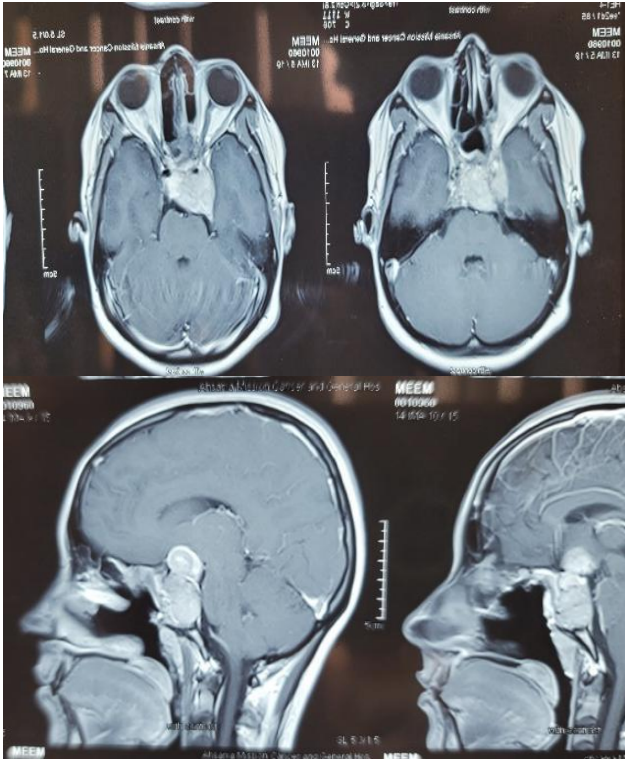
MRI of brain at 20th POD showing residual lesion measuring 2.4×2.3 cm.
